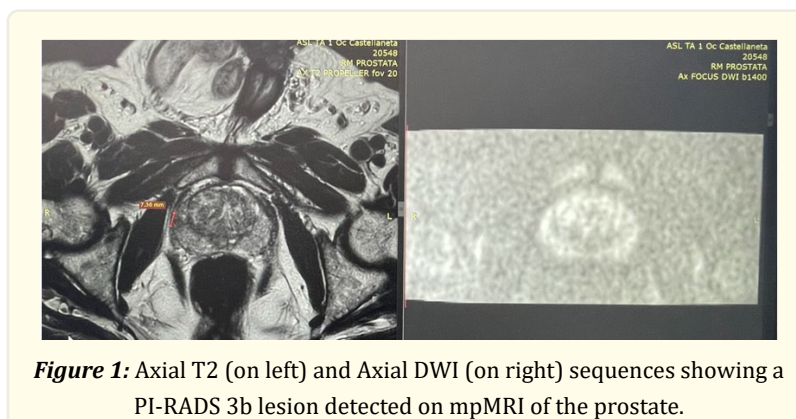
Axial T2 (on left) and Axial DWI (on right) sequences showing a PI-RADS 3b lesion detected on mpMRI of the prostate.
